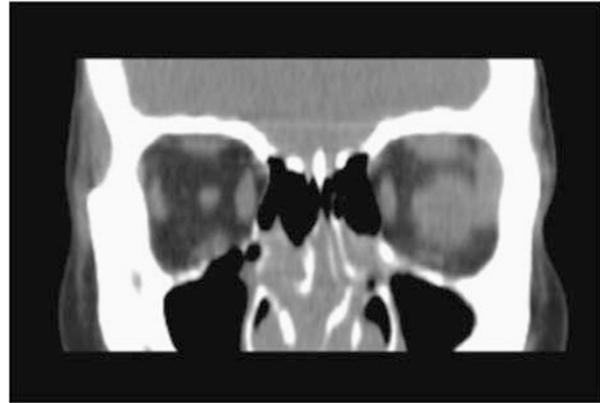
Coronal CT scan showing left lacrimal gland enlargement extending as far as posterior pole of globe. Bilateral sinus opacification also seen.
